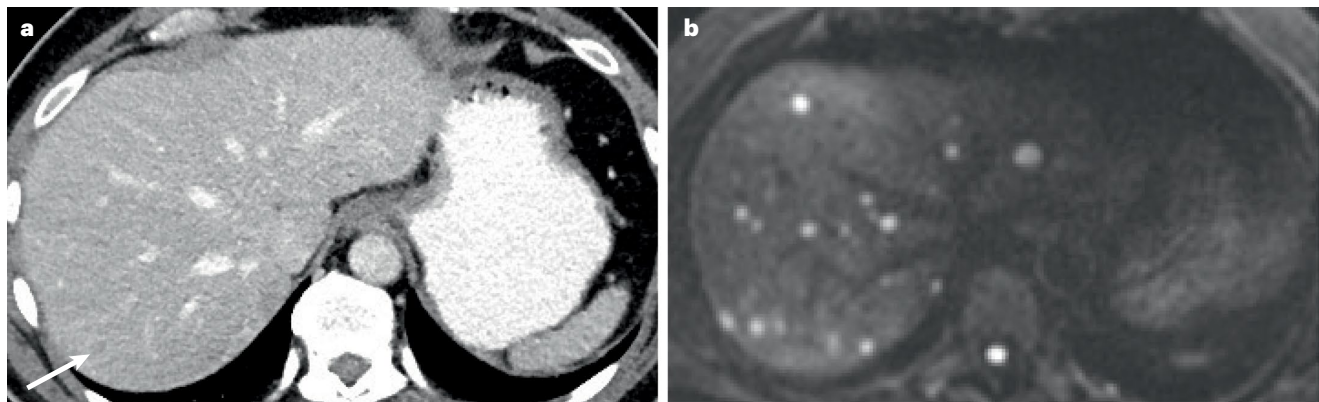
Detection of liver metastasis on CT and MRI imaging. a, CT image obtained during the portal venous phase with one indeterminate liver lesion in segment VII (arrow) in a patient with pancreatic cancer. b, MRI diffusion-weighted
